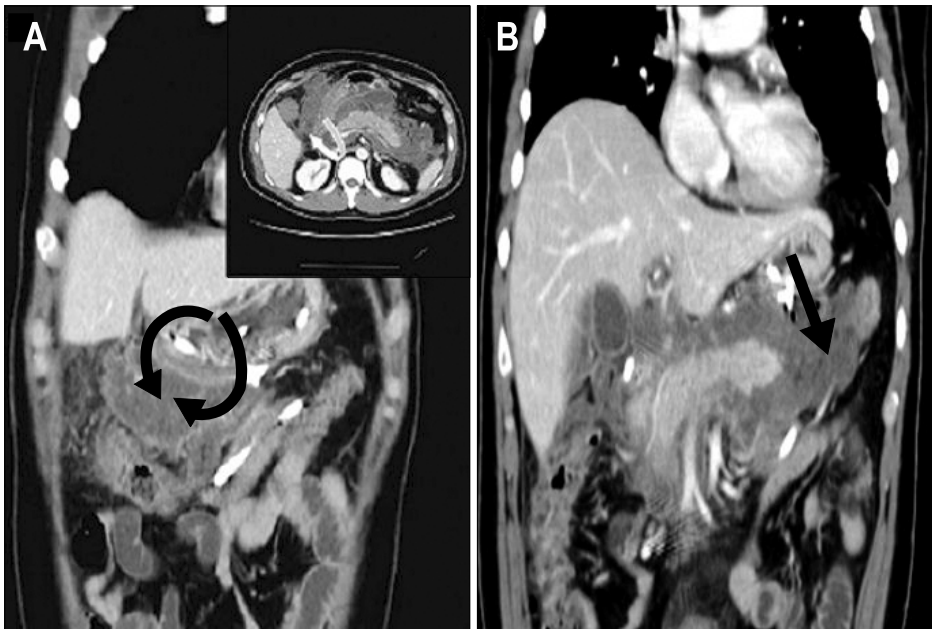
CT showing the concept of multitransgastric necrosectomy. (A) Necrosectomy of the peritoneal space (curved arrow). Inset: cross-sectional view of the transgastric approach to the peritoneal space. (B) Necrosectomy of the retroperitoneal space (arrow).
